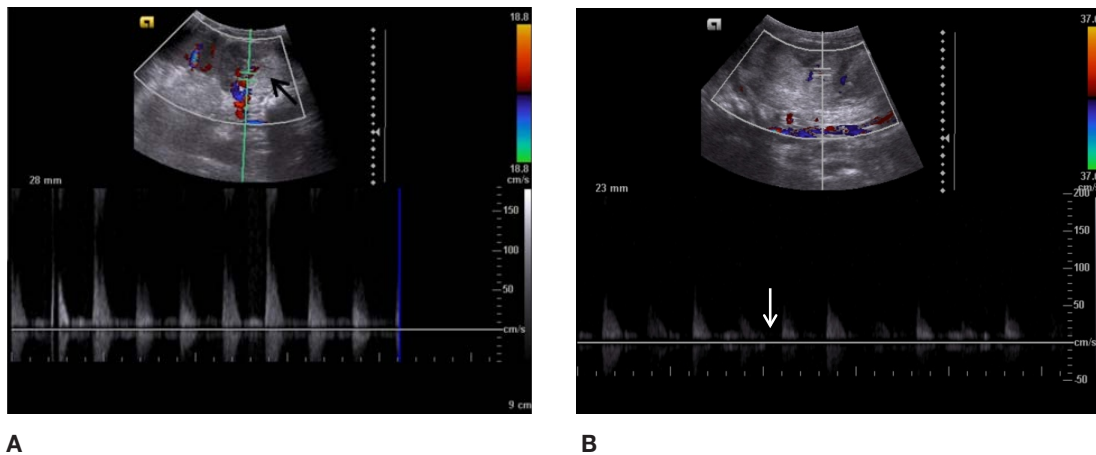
A – Doppler US: heterogeneity of the posterior aspect of the left kidney (arrow) with decreased vascularization of this area, preserved on the anterior aspect of the kidney. B- Doppler US: intrarenal resistive index (RI) was increased (near 1 – note the diastolic velocity near the baseline - arrow).
